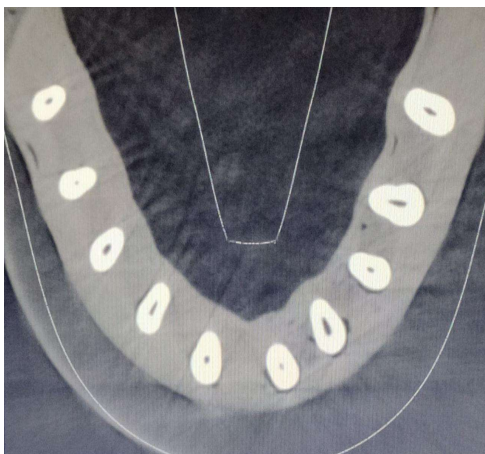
CBCT scan of decoronated section
